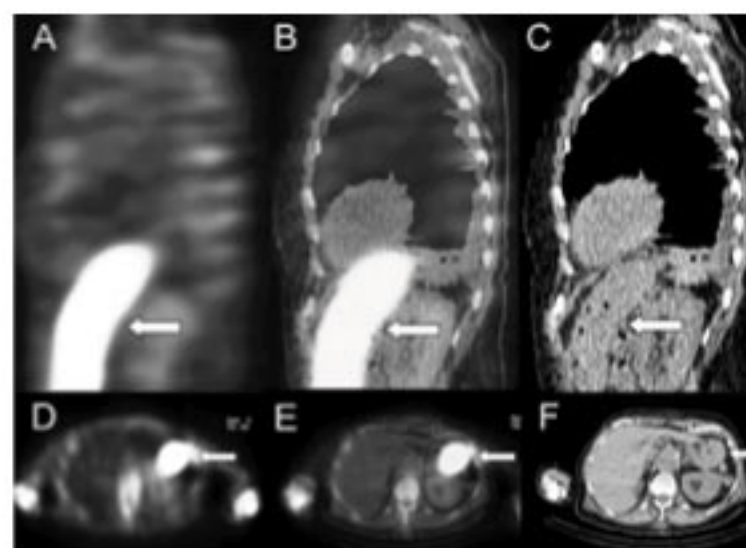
Differentiation between renal or gastric uptake of ^{99m}Tc-MDP and metastatic calcinosis using SPET/CT (A-F). A, Sagittal view of SPET; B, Sagittal view of SPET/CT; C, Sagittal view of CT; D, Transverse section of SPET; E, Transverse section of SPET/CT; F, Transverse section of CT; Arrows show the gastric anatomic location and radiotracer uptake.
